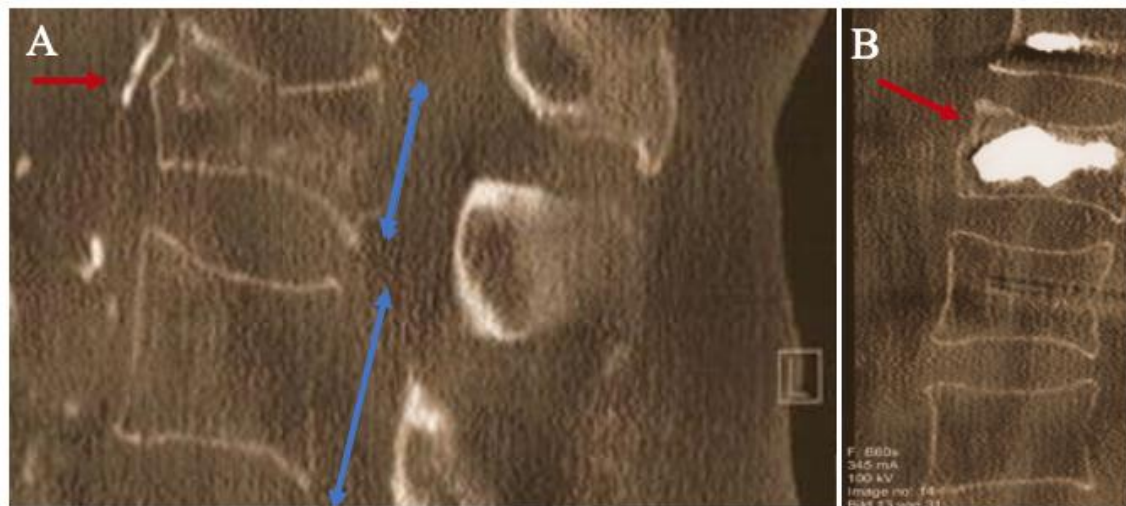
Case 3. (A) Sagittal reconstructed CT scan showing A.3.3 fracture (red arrow) and loss of vertebral height in comparison to next vertebral body (blue arrows) (B) Postoperative sagittal reconstructed CT scan of the same patient showing reduction and cement augmentation of the fracture (red arrow).
